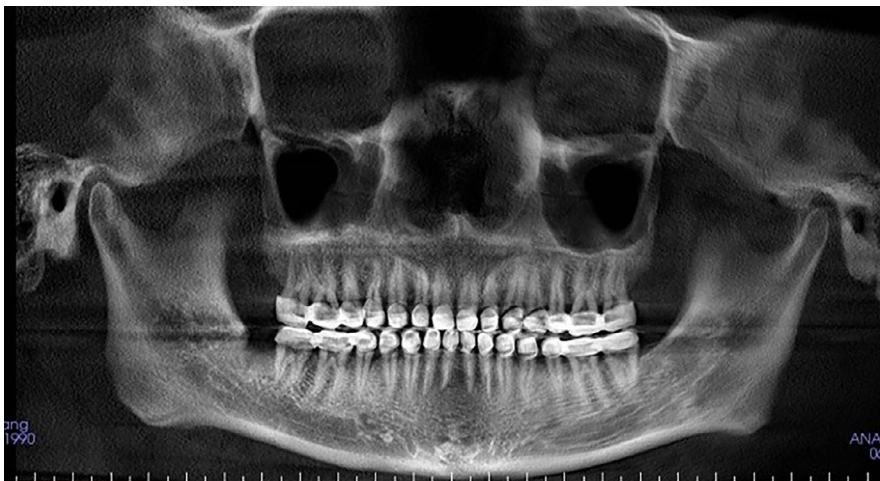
CBCT panoramic view of the patient after occlusal reconstruction
